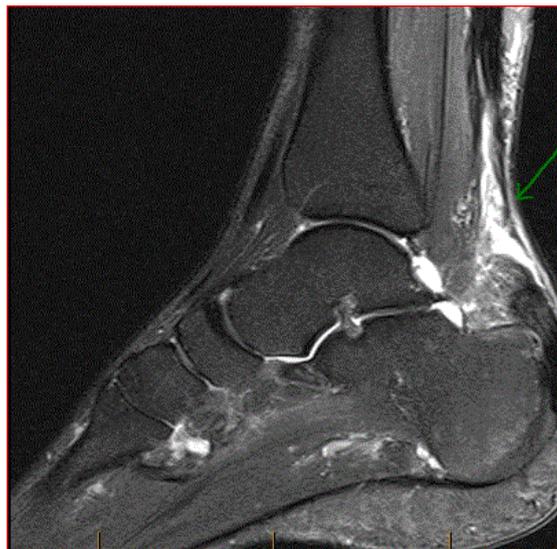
Sagittal T2 MRI Pre-surgery MRI demonstrating evidence of AT rupture
